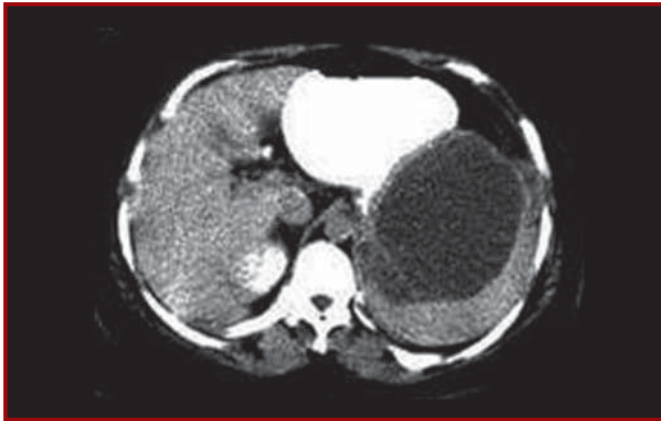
The magnetic resonance imaging appearance of the cystic splenic hamartoma
